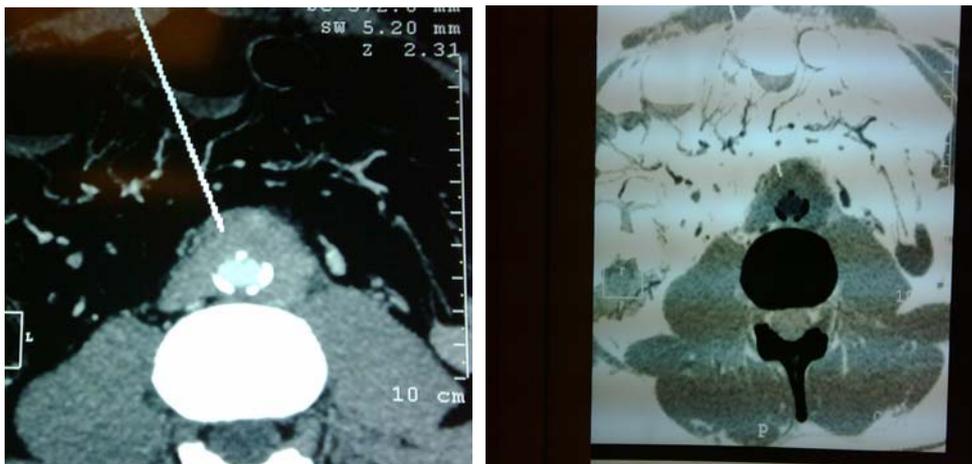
CT show retroperitoneal Para aortic mass at lower aortic root before bifurcation.
